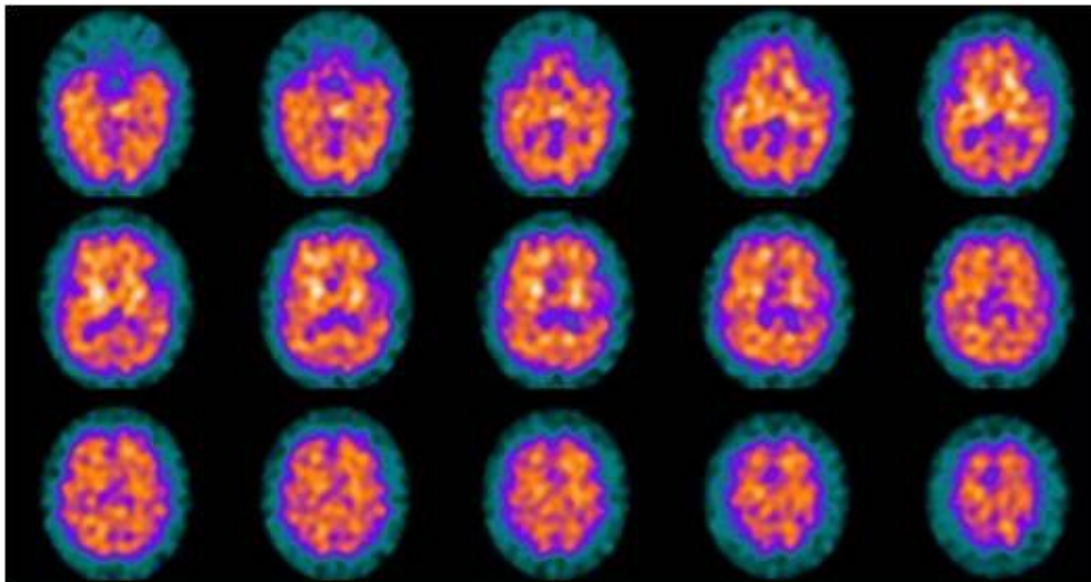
PET-CT images: D2 receptor occupation in the striatum by antipsychotics using ^{123}I IBZM scans and SPET.
